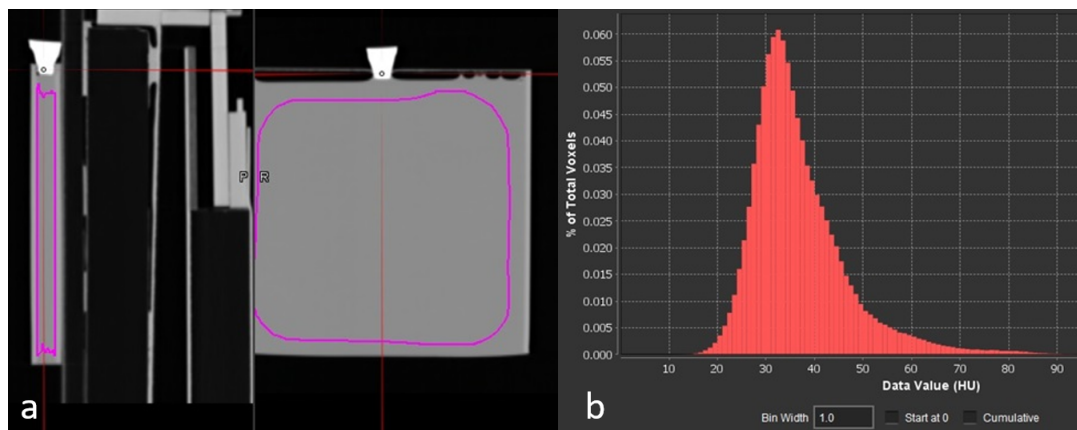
(a)CT scan of a cuboid ($150 \times 150 \times 10 \text{ mm}^3$) filled with gelatine. Contours in pink represent the selected part of the gelatine for analysis.(b)Histogram of the HU from the gelatine.
